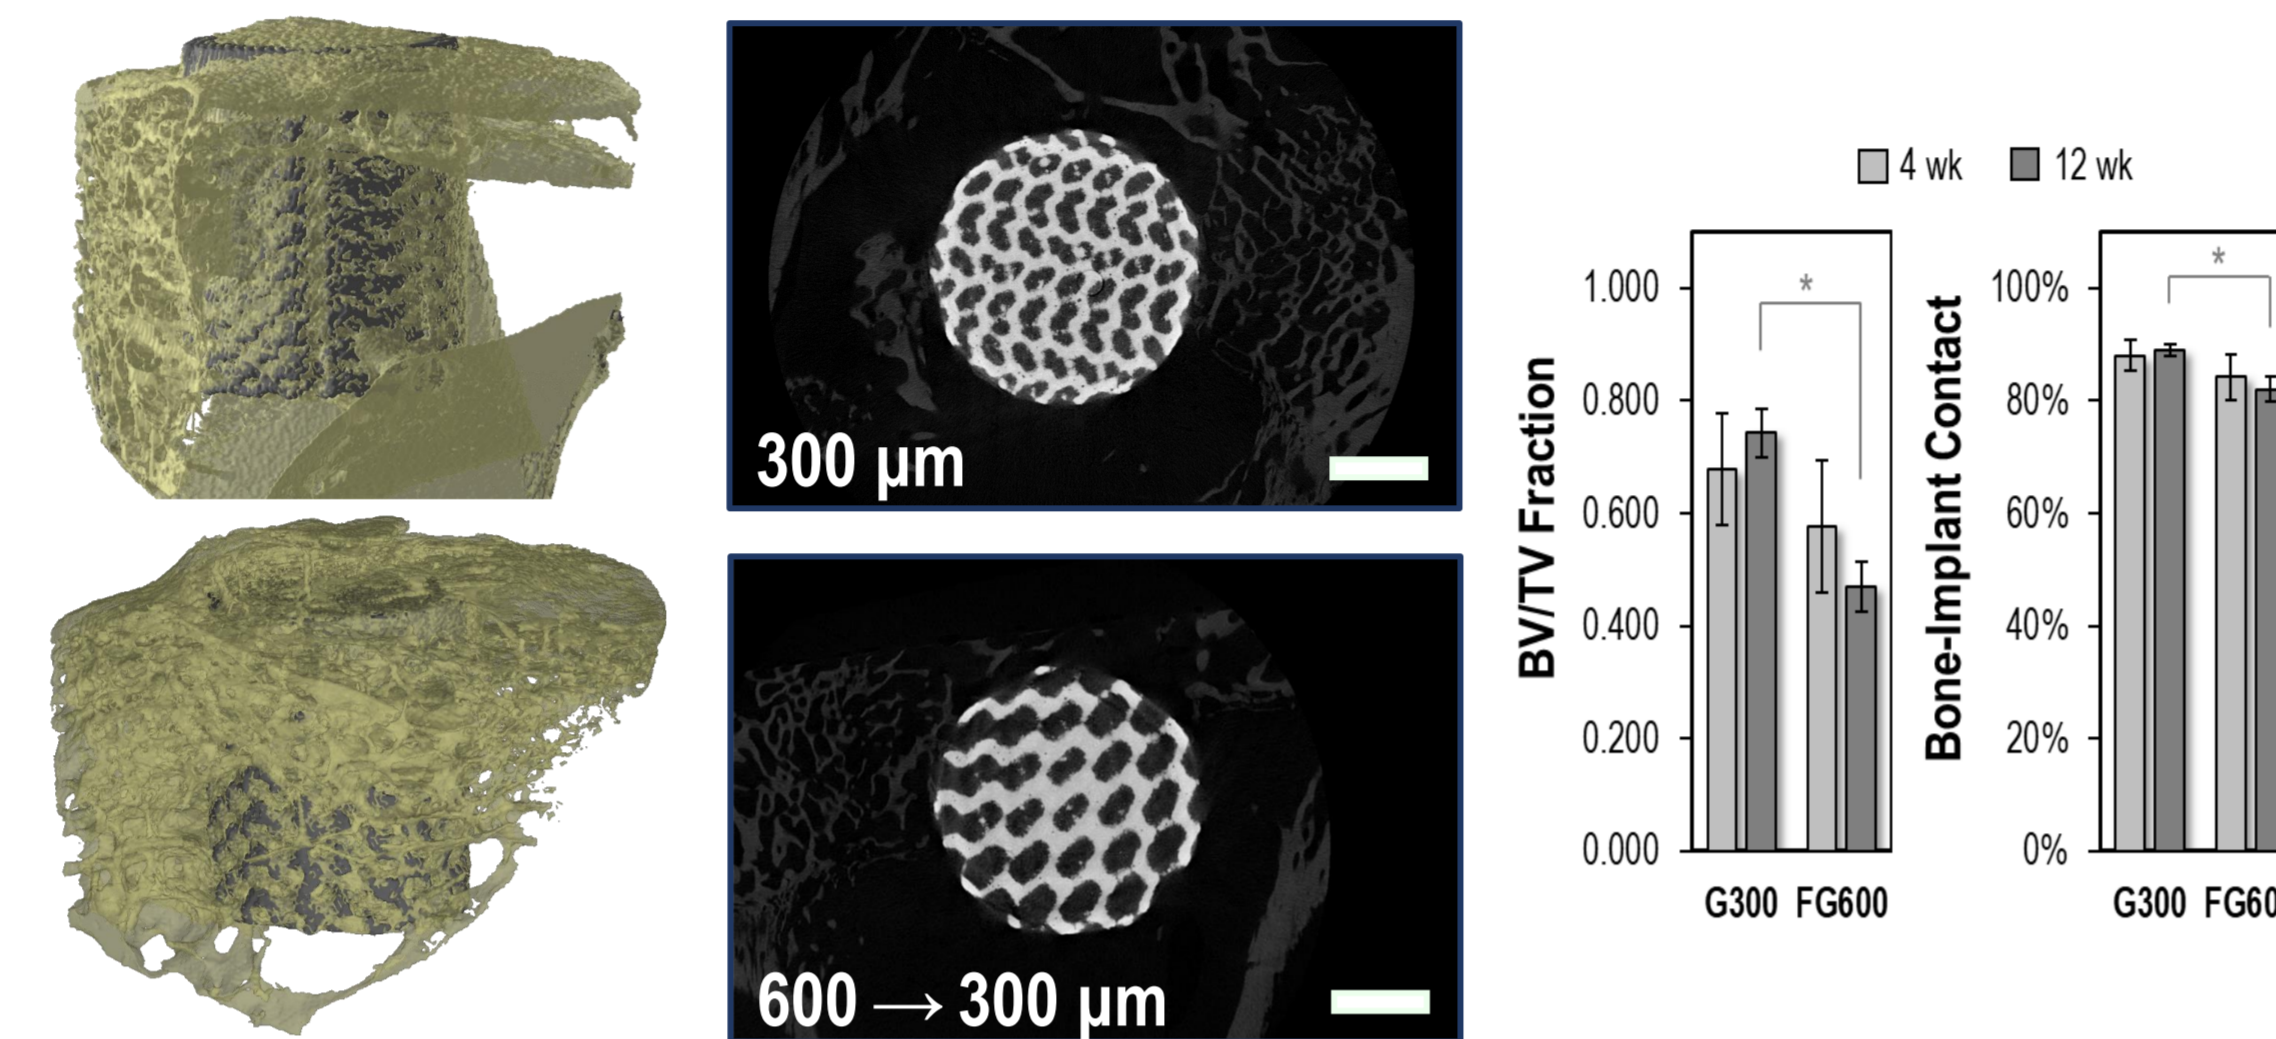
Microcomputed tomography reconstructions, representative slices and histomorphometric measurements of bone volume fraction (BV/TV) and bone-implant contact (BIC). Scale bars 2 mm.
